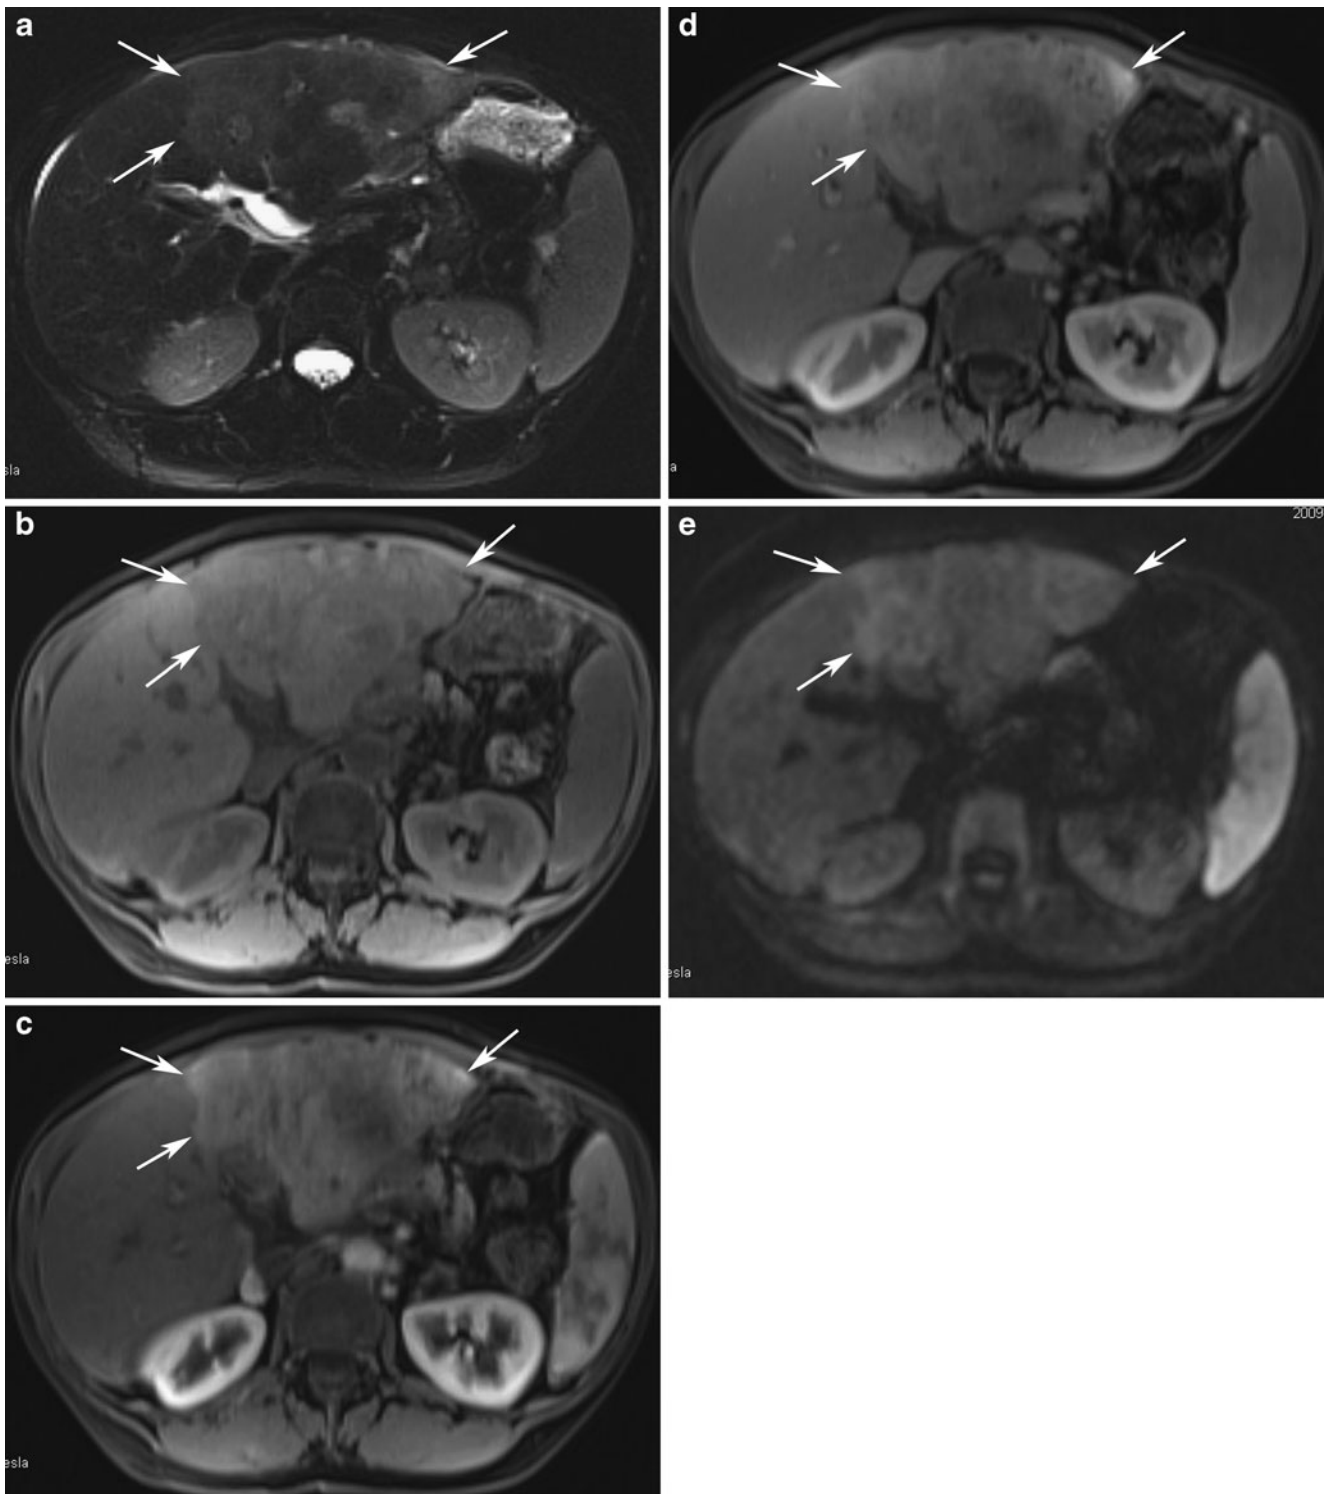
MR images of the same patient as above. a Axial T2-weighted fat saturation image shows subtle T2 hyperintense signal within the infiltrative HCC in the left hepatic lobe (*arrows*). b Axial precontrast T1-weighted GRE image shows corresponding low T1 signal in the left hepatic lobe tumor (*arrows*). c Axial postcontrast T1-weighted
